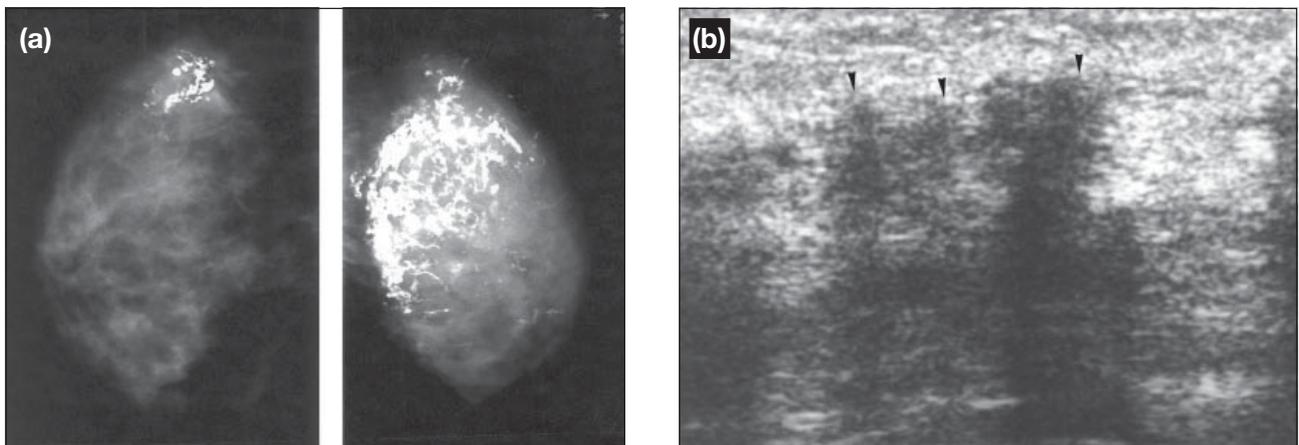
Fat necrosis. (a) A 25-year-old woman presented with a painful swollen left breast, clinically resembling inflammatory carcinoma. Cranio-caudal views of both breasts show extensive dystrophic calcifications, more severe on the left breast. (b) Ultrasound study shows extensive shadowing throughout the left breast (small black arrowheads), obscuring details. Core biopsy confirmed the diagnosis of fat necrosis.
